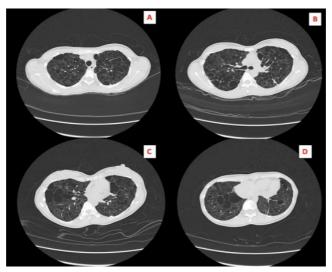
HRCT Thorax (A-D) showed bilateral diffuse cytic lesions of varying sizes
